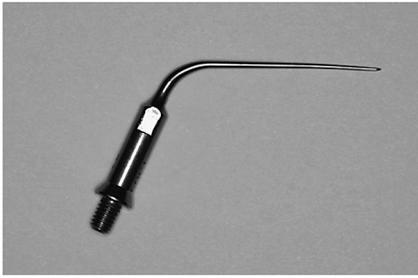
Osada No.1309 ultrasonic tip
